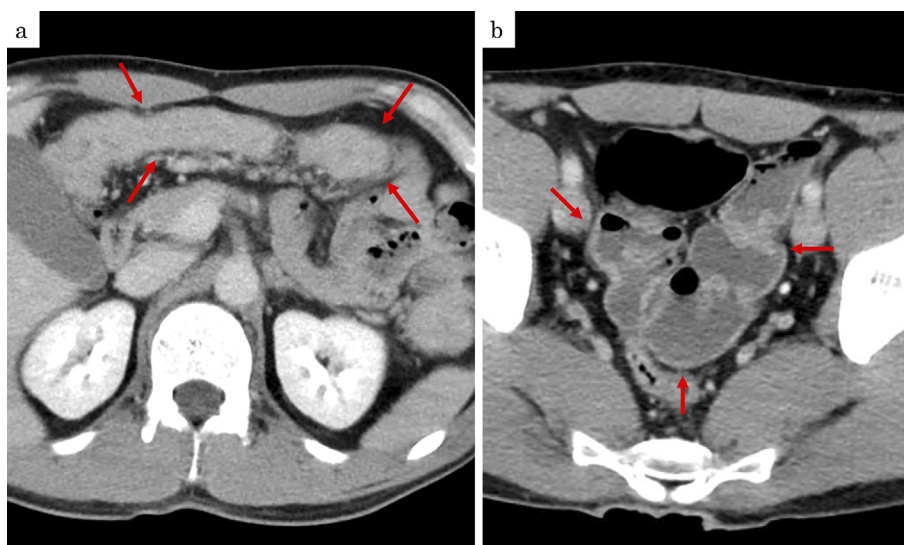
Abdominal computed tomography (CT) was performed upon admission. A CT scan revealed thickening of the mucosa from the transverse (a) colon to the sigmoid colon (b) due to ulcerative colitis (UC).
